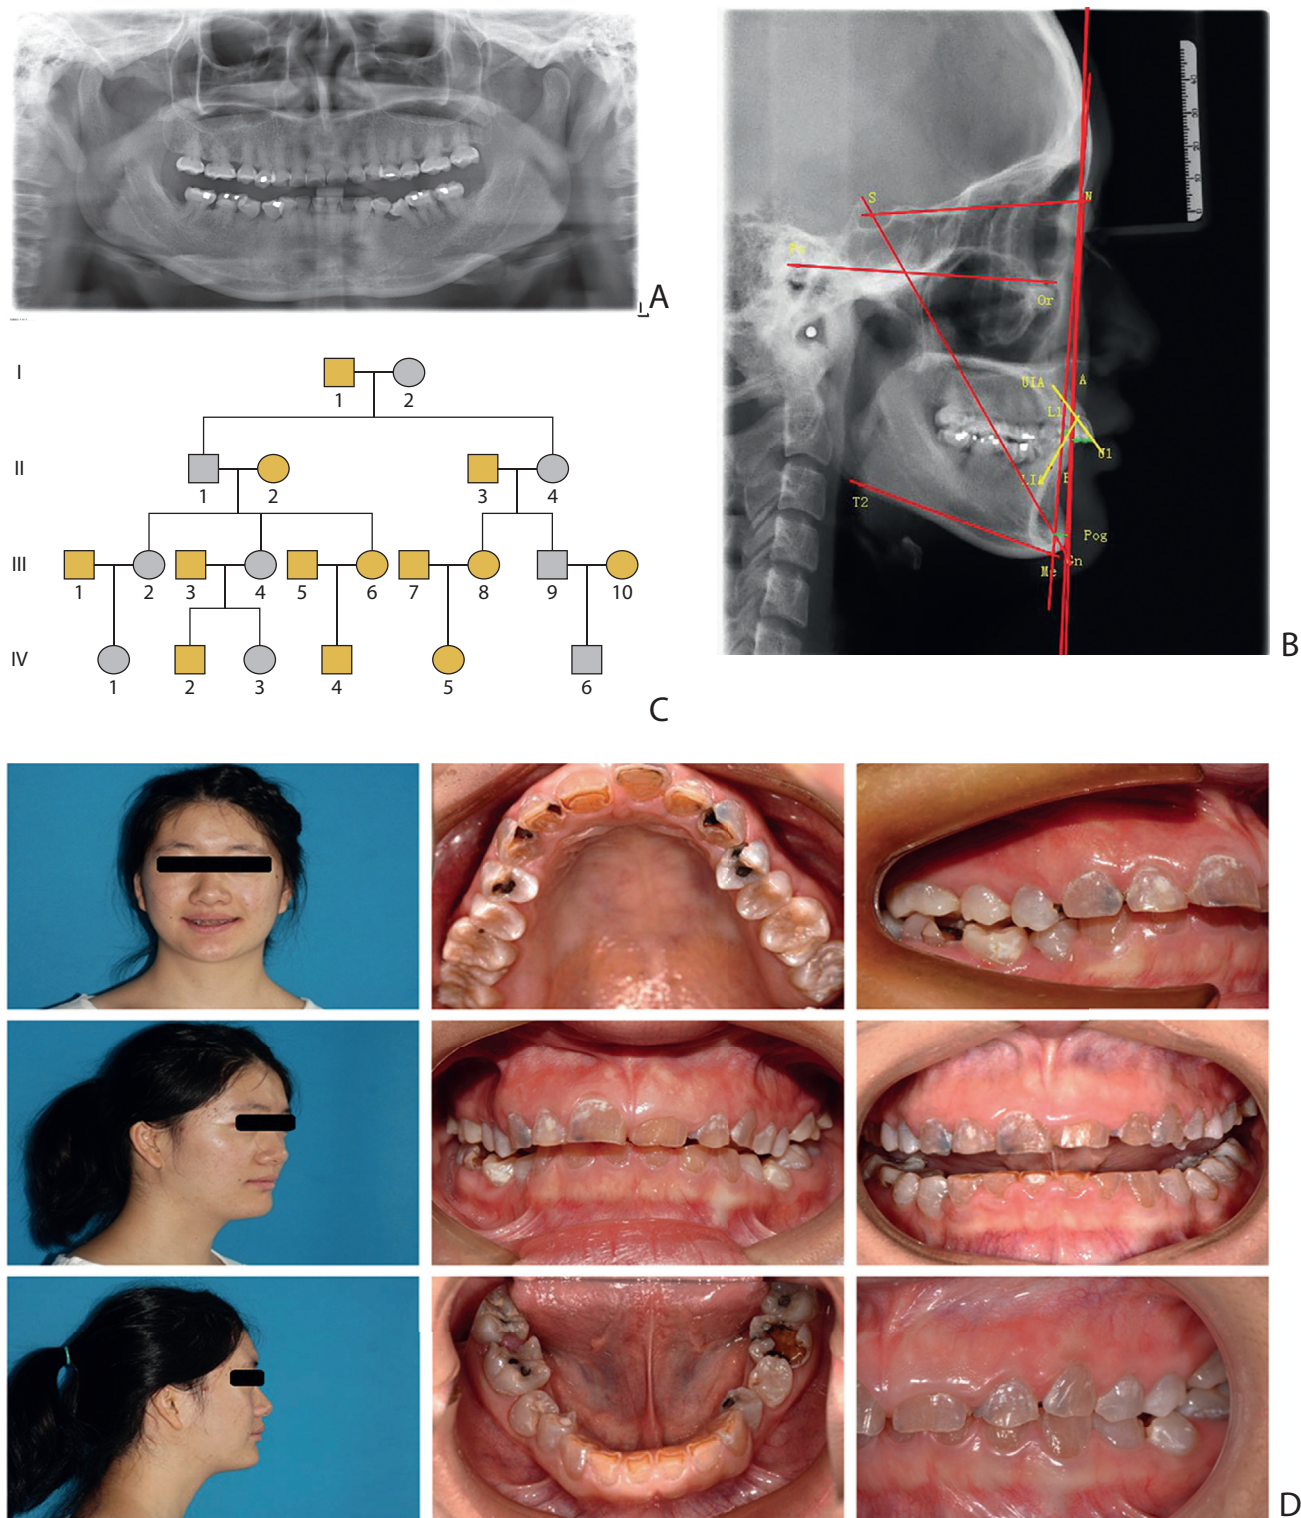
Clinical examination. A, Panoramic radiograph. B, Pretreatment lateral cephalogram and tracing. C, Family history. Each branch of family recorded separately. Patient is IV-1. D, Pretreatment facial and intraoral photographs.
